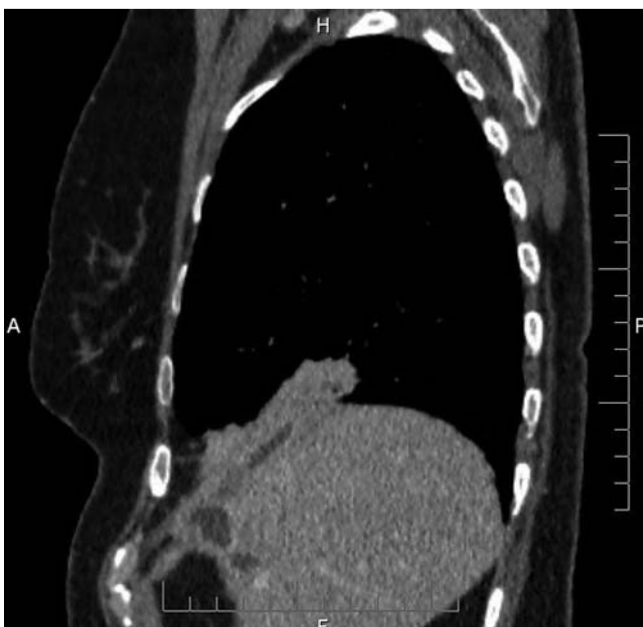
Thoracic computed tomography (CT) image after antibiotic therapy and endoscopic removal of the plastic biliary stents showing no signs of inflammatory lesions in the lungs.
